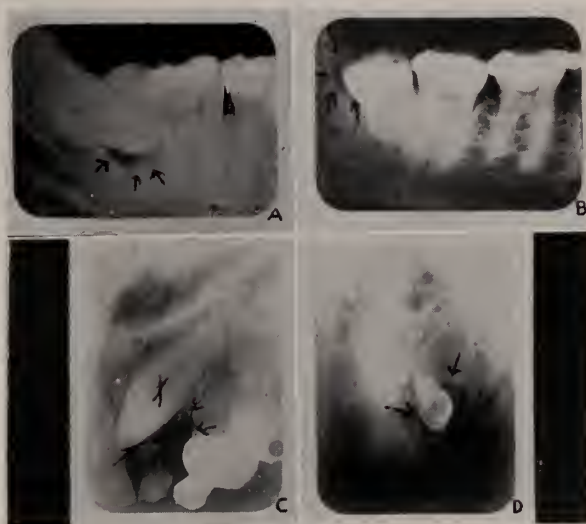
Roentgenograms showing infection about the crowns of impacted, unerupted and supernumerary teeth.
